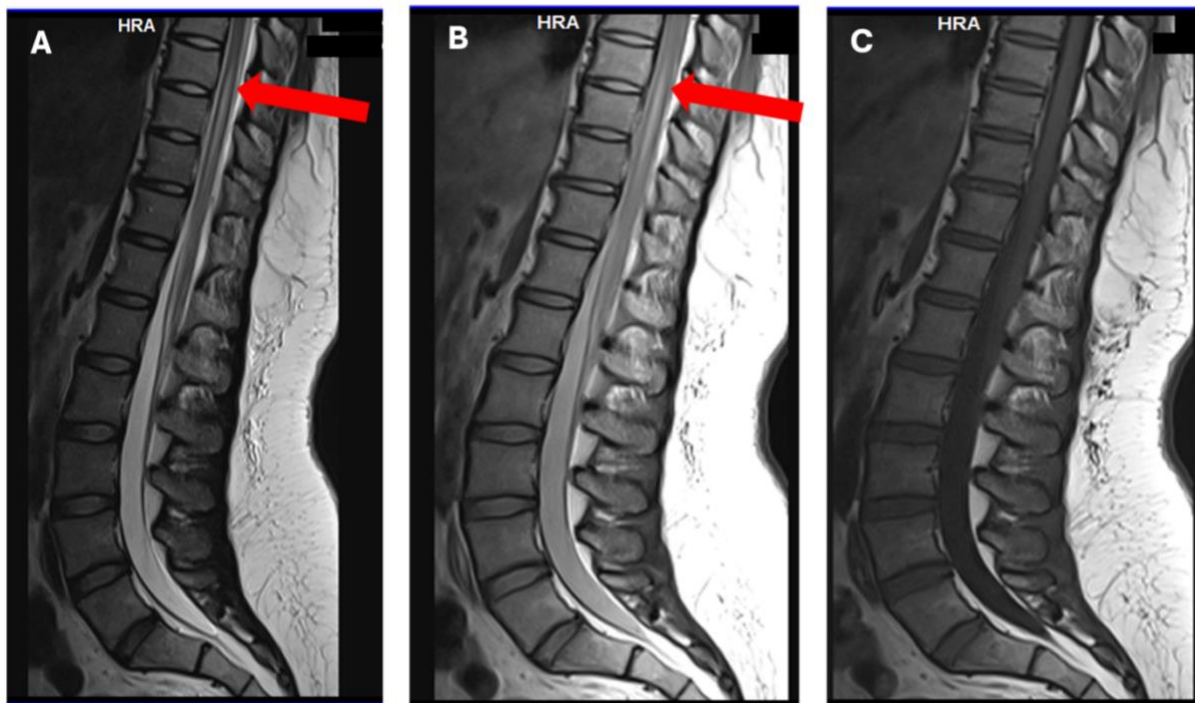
Thoracolumbosacral spine MRI sagittal view A) T2-weighted B) STIR/Short Tau Inversion Recovery C) T1- weighted
